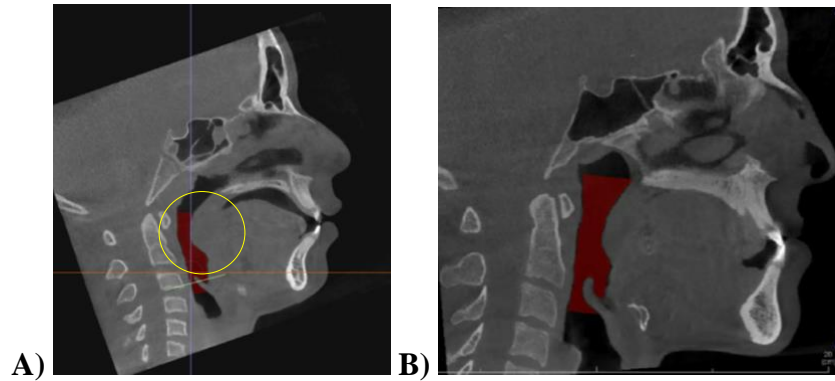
CBCT sagittal cross-sections depicting narrowed airway in a patient with A) retruded tongue position and B) normal (non-retruded) tongue position
